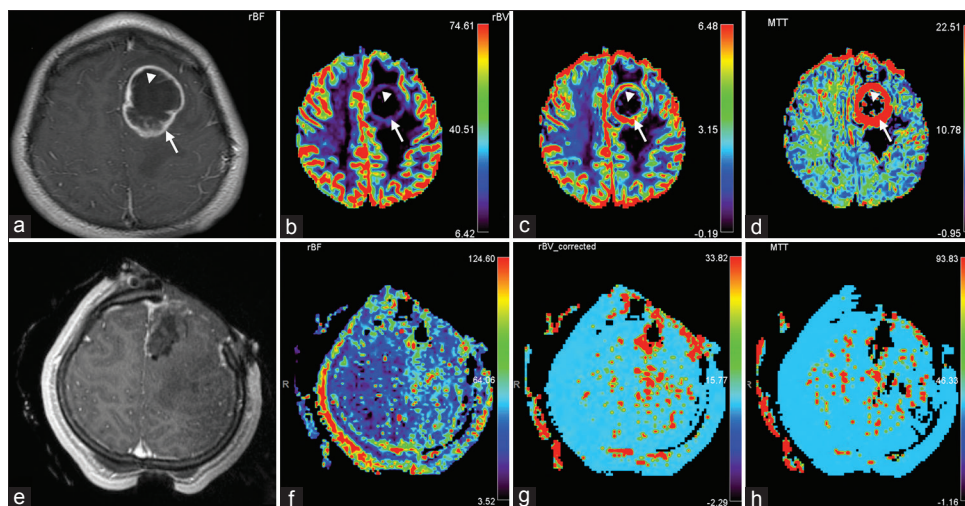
Preoperative and intraoperative MR perfusion of RELA-fusion positive ependymoma. Preoperative (a) T1-weighted with contrast, (b) CBF, (c) CBV, and (d) mean transit time (MTT) imaging demonstrates increased diffusion in the ring-enhancing portion of the tumor, suggestive of an aggressive lesion (arrow). This perilesional area (arrow) correlated with the solid tumor component seen on pathological analysis [Figure 3a–c]. A central hypoperfusive tumor mass (arrowhead in a–d) correlated with the more papillary component of the tumor [Figure 3d–f]. Intraoperative (e) T1-weighted contrast-enhanced imaging suggested a gross total resection. However, intraoperative (f) CBF, (g) CBV, and (h) MTT demonstrated posterior perilesional hyperperfusion that was suggestive of residual tumor, a conclusion that was later confirmed
